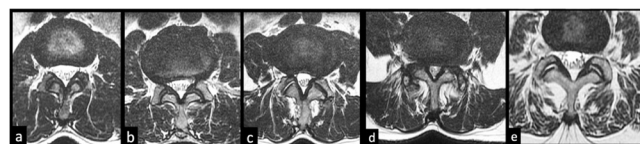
Grade of multifidus muscle fatty infiltration based on goutallier grading (range 0 to 4) on axial T1-weighted image. (a) Grade 0: normal muscle tissue. (b) Grade 1: fat streaks. (c) Grade 2: more muscle than fat. (d) Grade 3: equal amounts of fat and muscle tissue. (e) Grade 4: more amount of fat than muscle.
